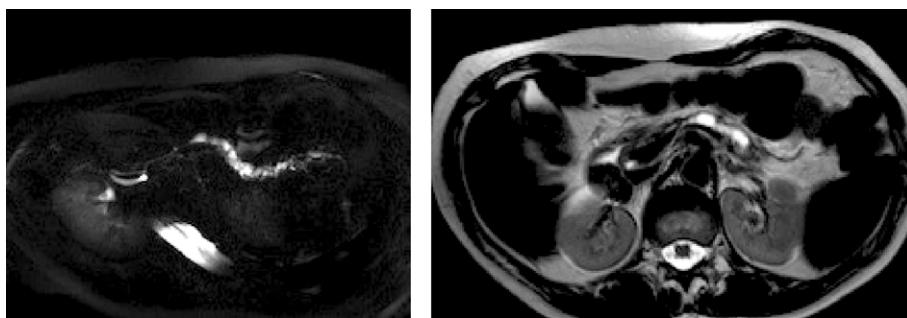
Main duct IPMN mimicking obstructive chronic pancreatitis. Irregular dilatation of corporeo-caudal main pancreatic duct with parenchymal atrophy as shown by axial 2D MRCP imaging (a) and T2-weighted imaging (b).
